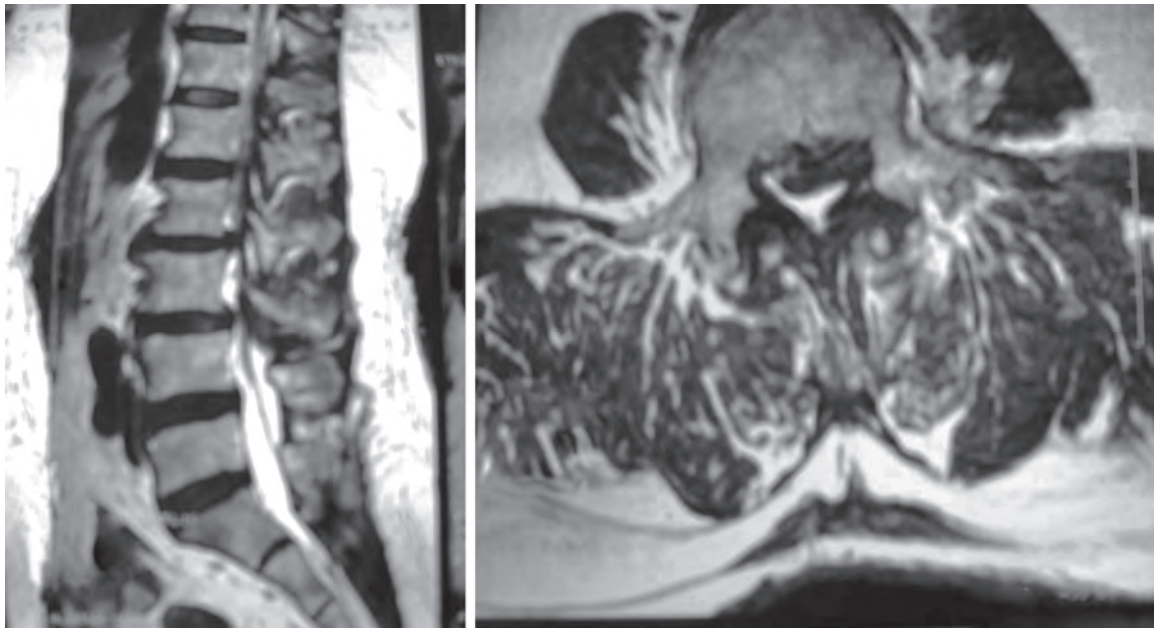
MRI of the lumbar spine showing sagittal and axial view of a degenerative spine with ligamentum flavum hypertrophy, disc protrusion and facet hypertrophy causing severe canal narrowing
